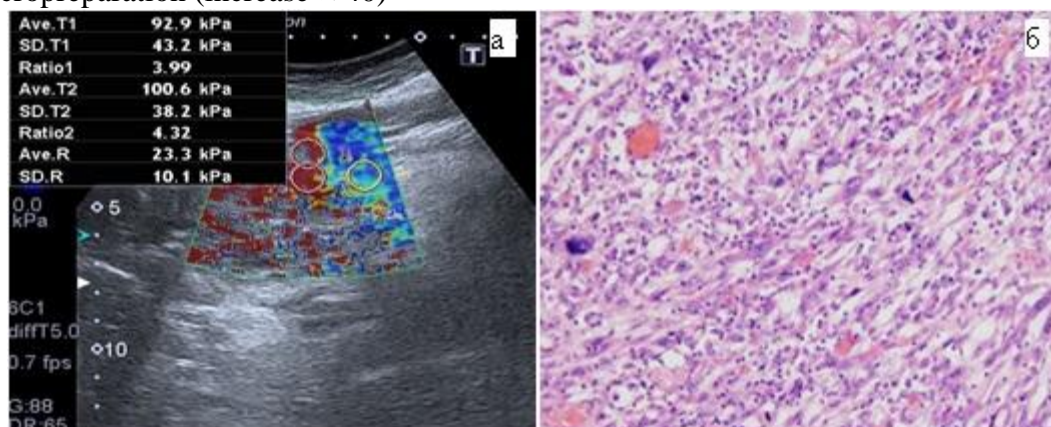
Mucinous cystadenocarcinoma of the pancreas. a — CT and ultrasonic diffraction pattern, elastography. b — micropreparation (increase $\times 40$)
